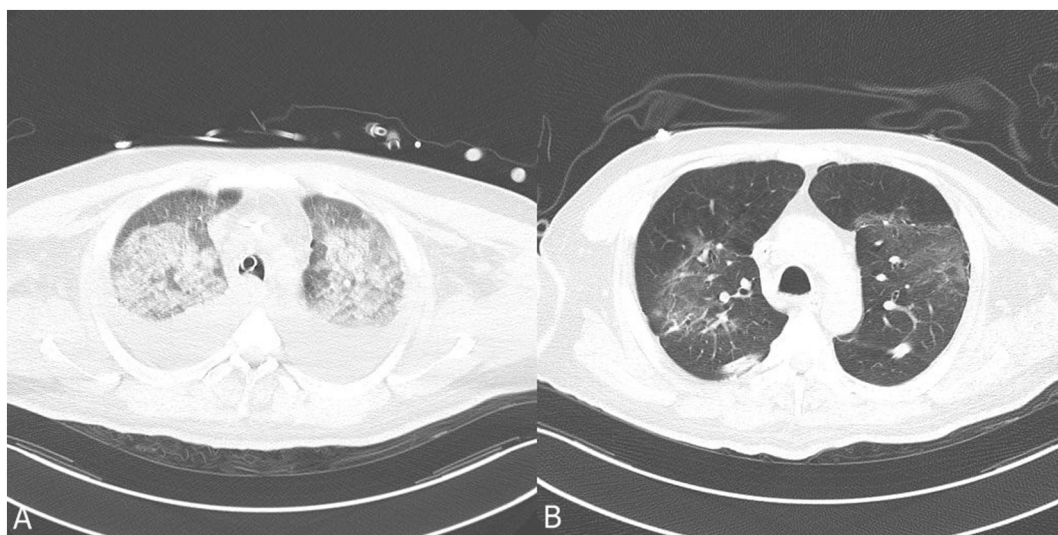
(A) On the fourth postoperative day, the patient's CT scan showed progressive lung infiltration and both pleural effusions. (B) There was a sequela of lung injury in the CT taken one month later.
